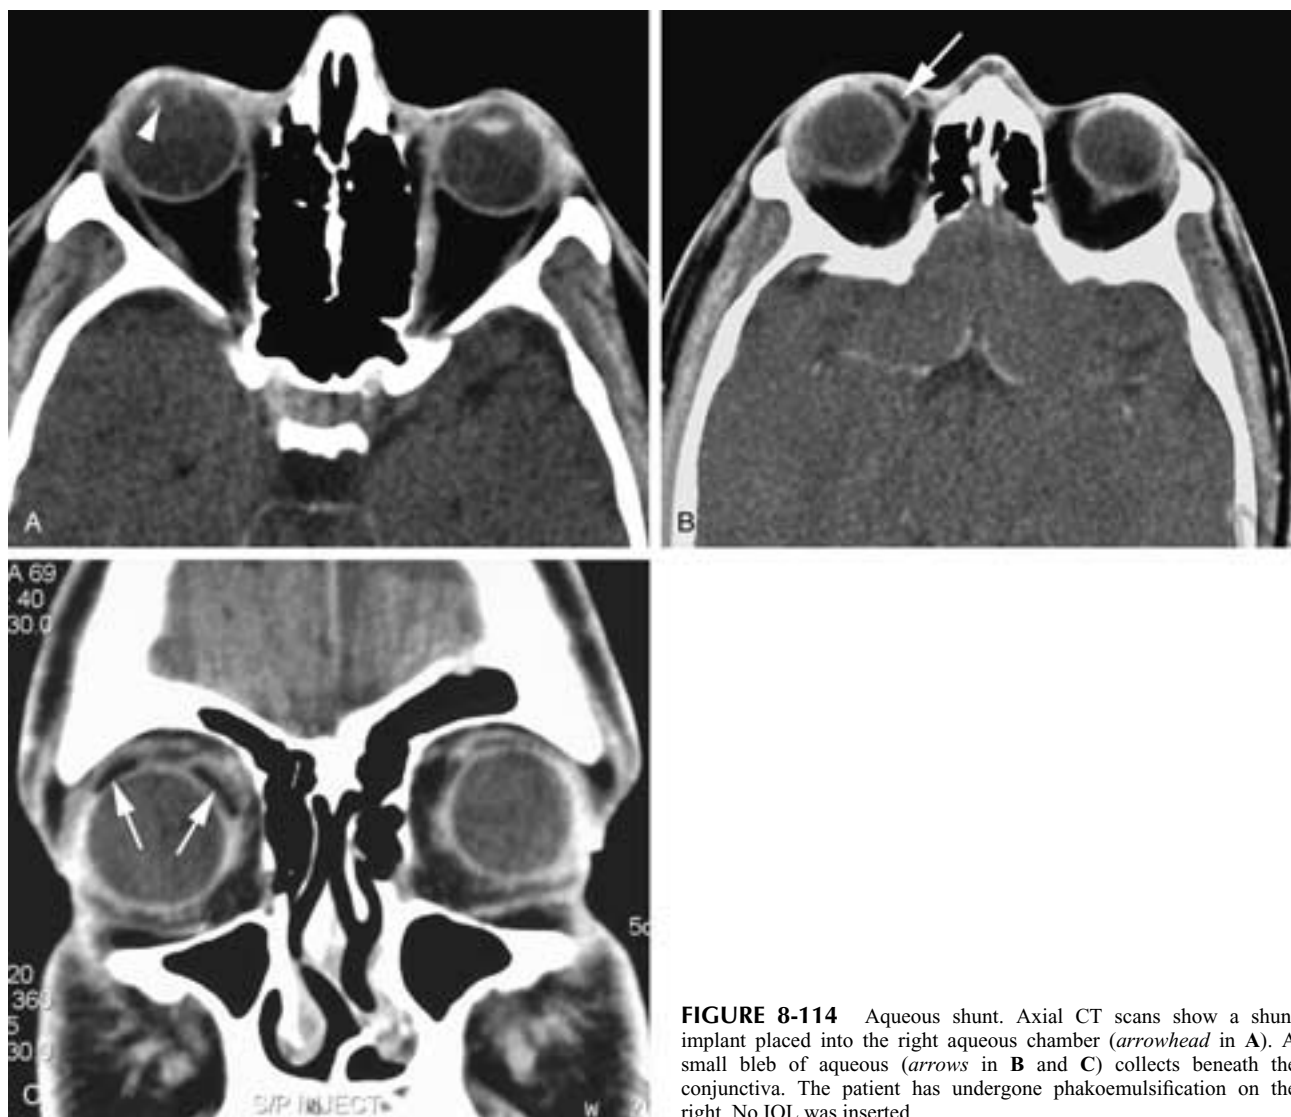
Aqueous shunt. Axial CT scans show a shunt implant placed into the right aqueous chamber (arrowhead in A). A small bleb of aqueous (arrows in B and C) collects beneath the conjunctiva. The patient has undergone phakoemulsification on the right. No IOL was inserted.
